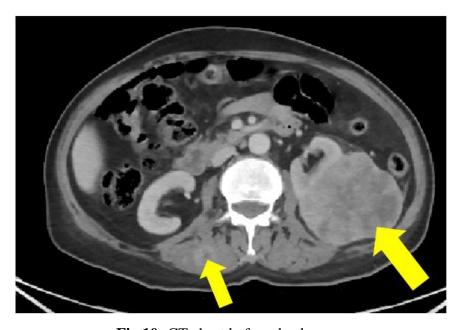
CT chest before death
